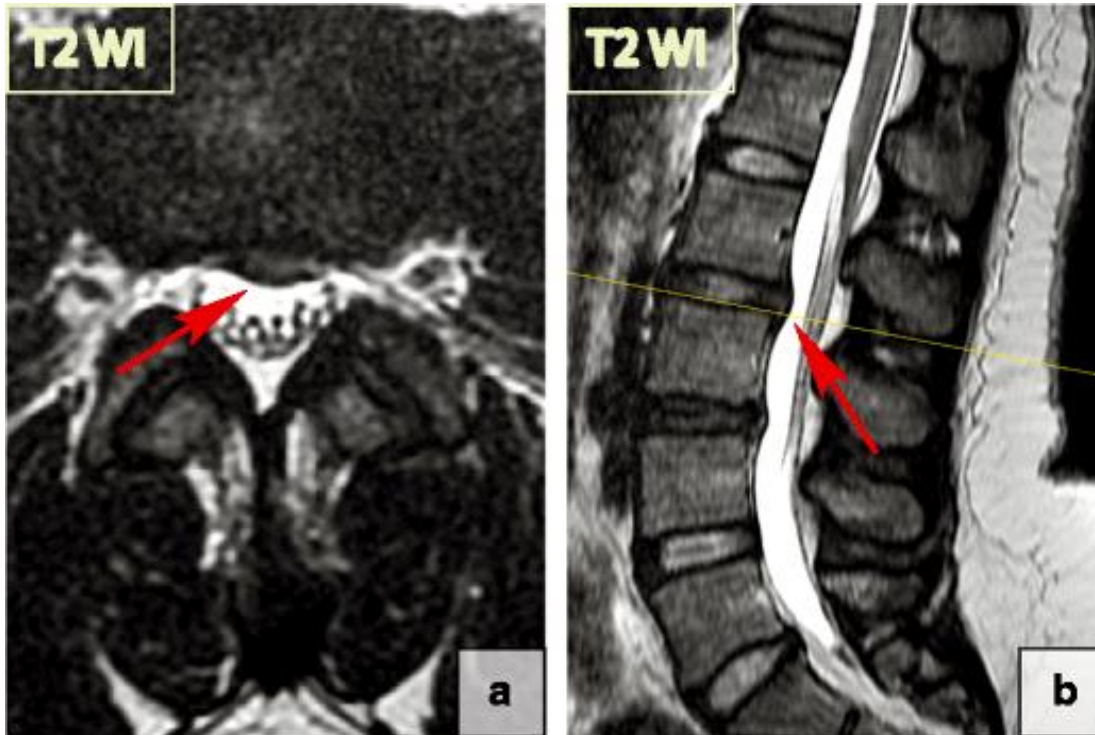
Focal disc displacement protrusion. T2-WI (a+b) axial and sagittal MRI of lumbar spine scans demonstrate focal left L2-L3 paracentral posterior protrusion. There is no disruption of the fibres of the overlying annulus fibrosus or the posterior longitudinal ligament.
